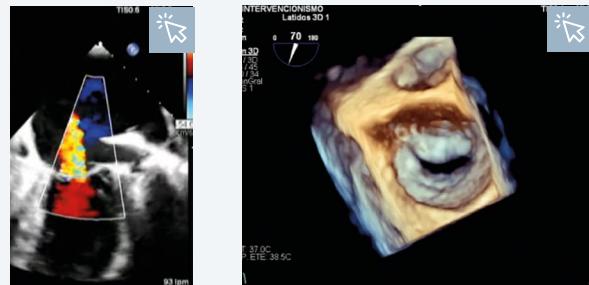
Baseline transoesophageal echocardiograms showing central MR and good quality leaflets.²⁷
